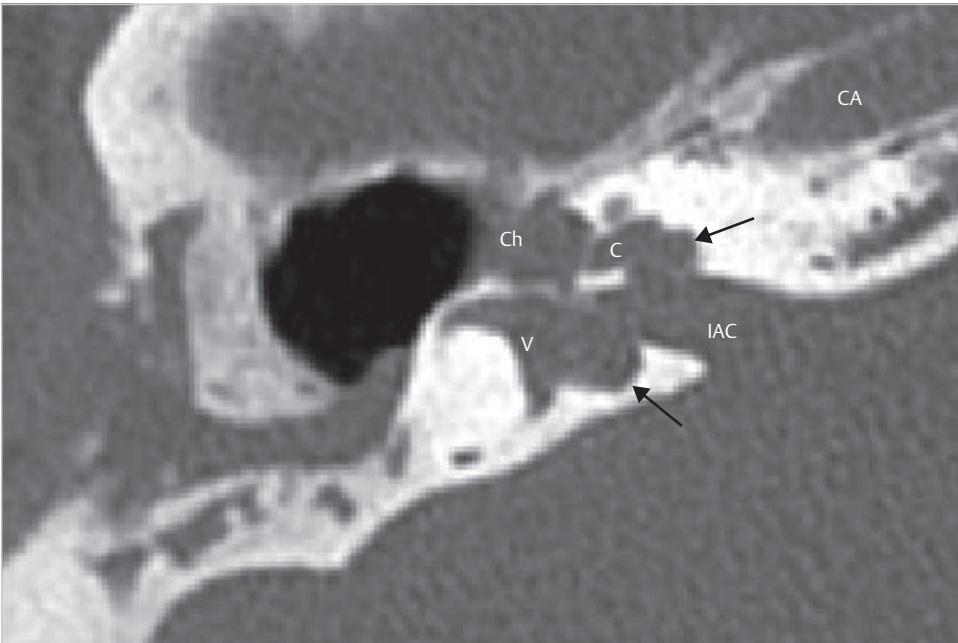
Despite fair bone conduction, the axial CT at the level of the internal auditory canal shows erosion of both the cochlea and the vestibule by the cholesteatoma extended medially to the labyrinth. C, cochlea; CA, carotid artery; Ch, cholesteatoma; IAC, internal auditory canal; V, vestibule.
